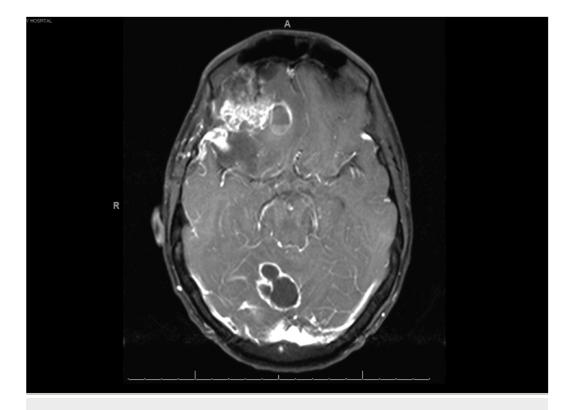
MRI Five Months After Initial Presentation
